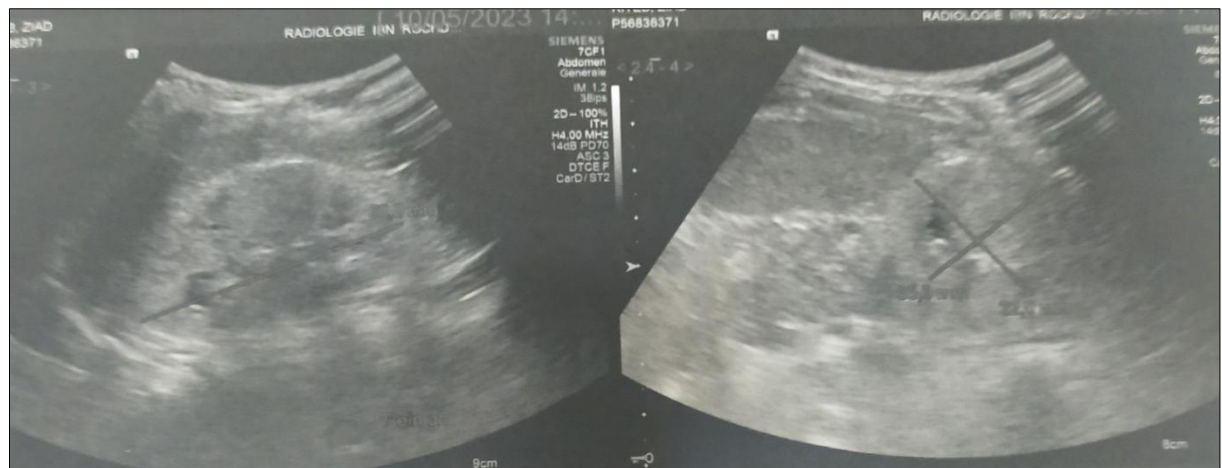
Left renal ultrasound ultrasonography showing an appearance in favor of chronic kidney disease: the left kidney is slightly reduced in size with regular contours and an echogenic cortex, moderately differentiated, measuring 60 × 30 × 32 mm
